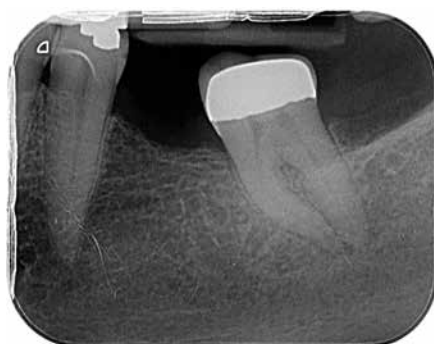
LL7 pre-operative radiograph.
